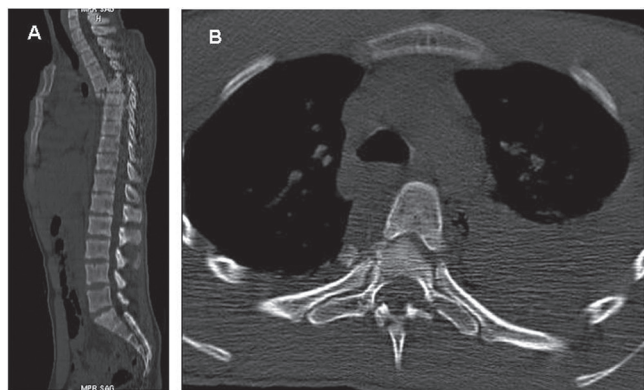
A: On sagittal computed tomography (CT), complete anterior dislocation at the T5-6 level and complete disruption in the spinal cord are seen. B: On axial CT, T5-6 spondyloptosis is seen.
